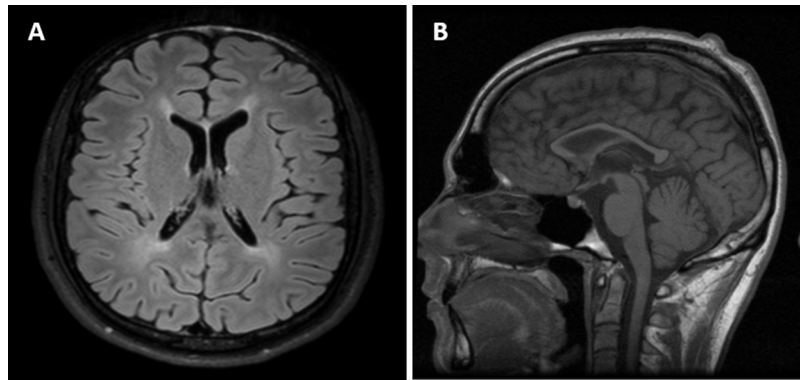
Magnetic resonance imaging study. A) Axial T2-FLAIR sequence showing periventricular white matter hyperintensity. B) T1-weighted sequence showing global atrophy, with marked atrophy of the corpus callosum.
